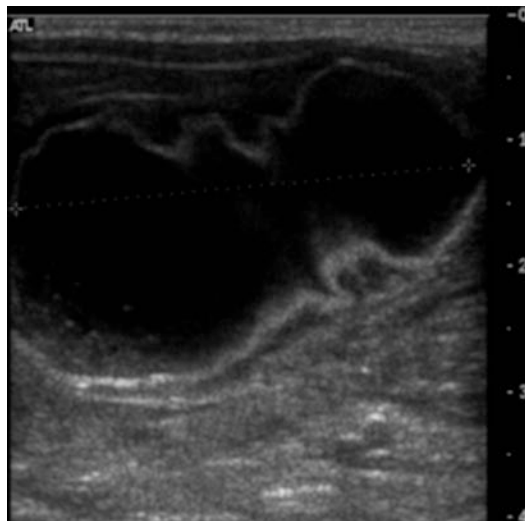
Sonographic appearance of a pedunculated cystic duplication arising from the posterior gastric wall. Note the characteristic gastrointestinal wall three-layer sonographic signature
